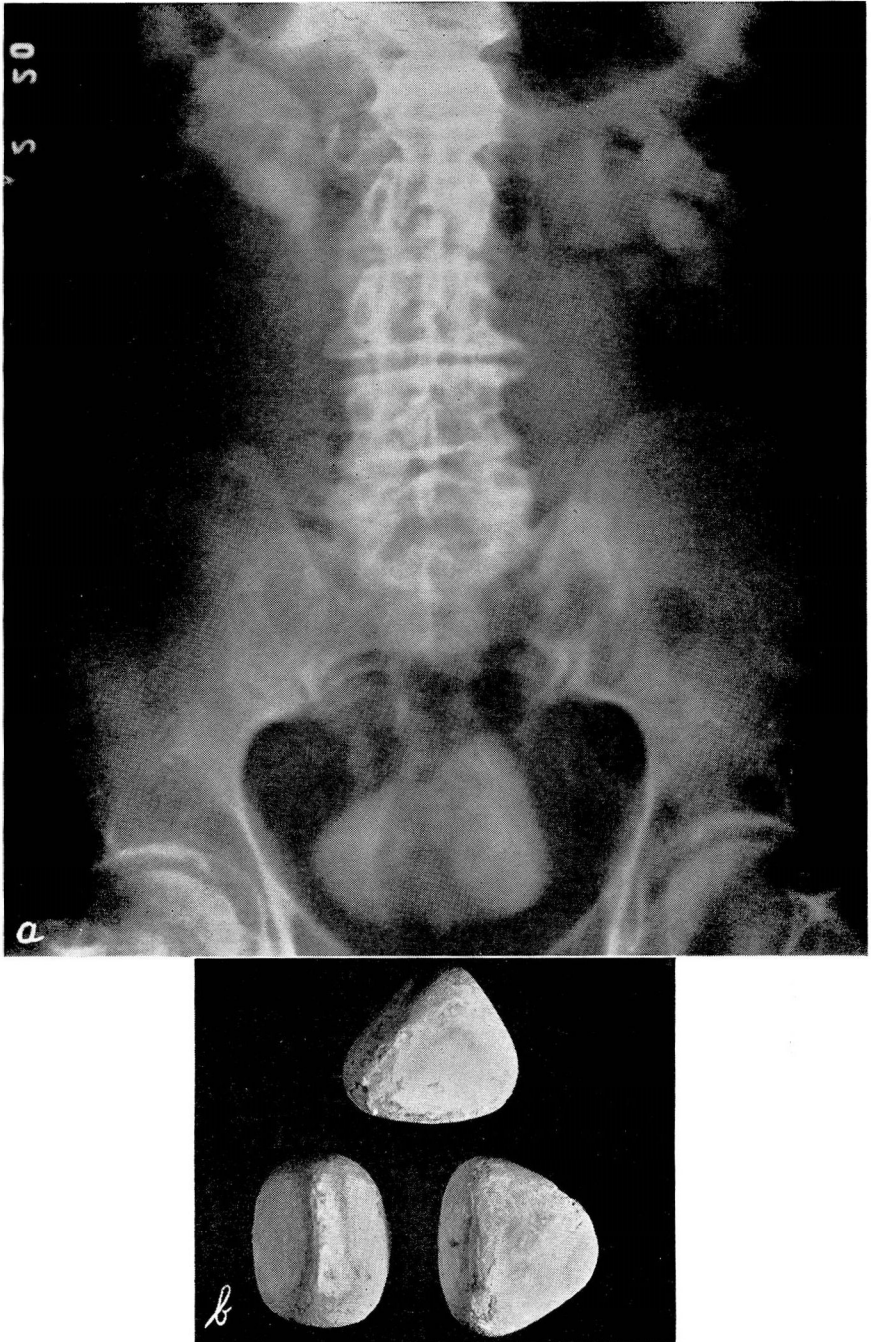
a. Roentgenogram showing three large calculi present in the bladder and the resultant ureteral and kidney disease.
